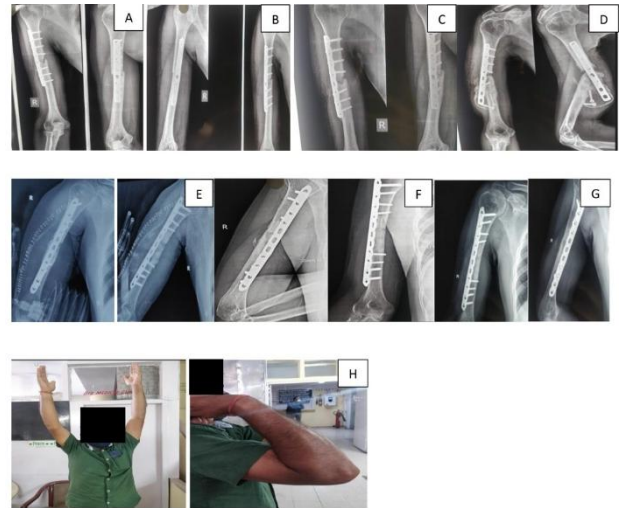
33 male with implant failure managed with compression plating and iliac bone grafting: (A) X-ray on day 14 of fixation of midshaft fracture humerus, (B) X-ray at 3 months depicting no callus, (C) X-ray at 6 months showing signs of non-union, (D) X-ray at 9 months showing implant failure, (E) immediate post-operative after compression plating and iliac bone grafting, (F) 3 months post-operative depicting good radiological union, (G) 10 month X-ray showing union, and (H) 10 month follow-up depicting good comparable functional outcome.
